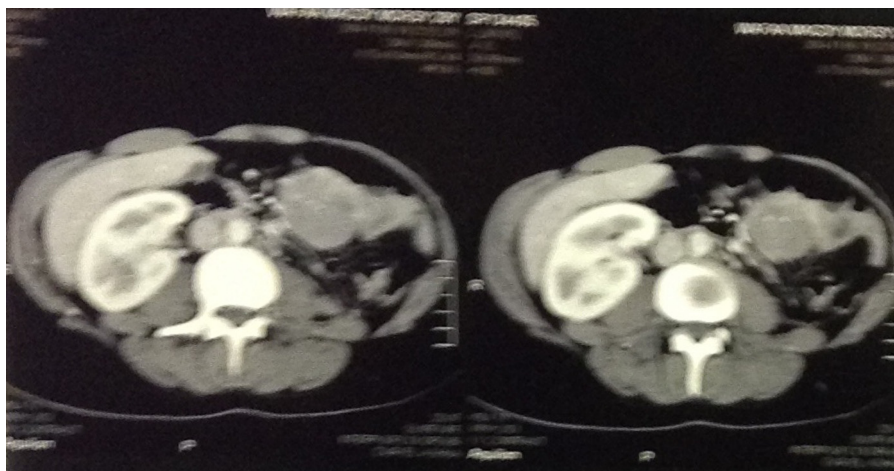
CT image showing a recurrent tumour within the mesentery.
